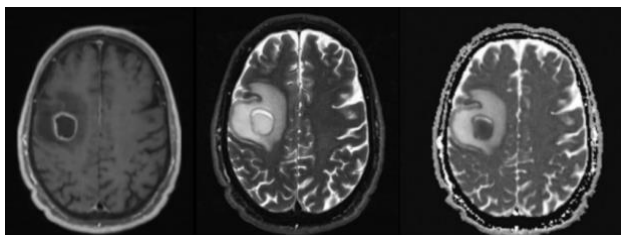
The cerebral magnetic resonance imaging (MRI) shows a right frontal/precentral abscess.
